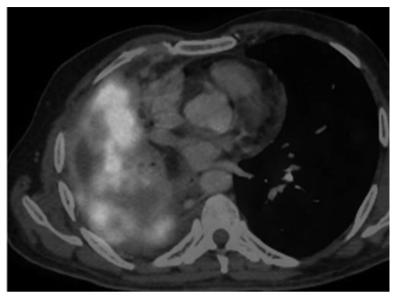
Input lung CT image.
